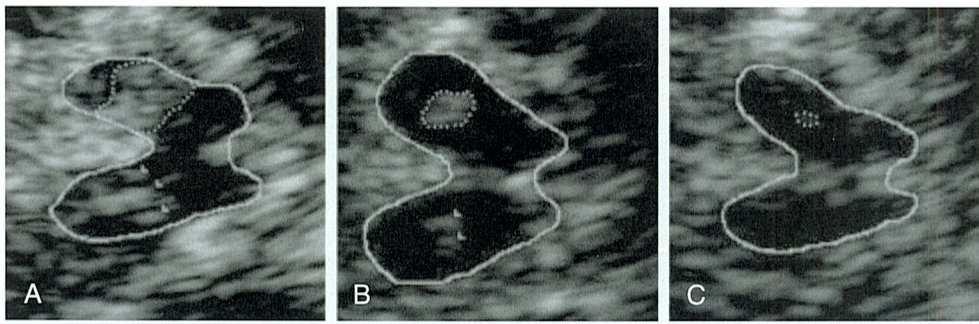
Decreased iron concentration in substantia nigra (SN) of restless legs syndrome (RLS) patients (transcranial sonography). Representative ultrasound images of the human mesencephalic brainstem. SN (encircled with *dotted line* on the side of insonation and marked contralaterally with *arrowheads*) appears hyperechogenic in the hypoechogenic brainstem area (*solid line*). A, Patient with Parkinson's disease (PD), showing SN hyperechogenicity (SN area $\geq .19$ cm² on one or both sides), which is typical for idiopathic PD. B, Healthy control, showing a regularly sized SN area of echogenicity. C, RLS patient, showing hypoechogenic SN (SN sum area of both sides ≤ 0.2 cm²); SN is often not delineable contralaterally. (From Godau J, Schweitzer KJ, Liepelt I, Gerloff C, Berg D. *Substantia nigra hypoechogenicity: definition and findings in restless legs syndrome*. *Mov Disord*. 2007;22:187-192. Copyright 2007, with permission from John Wiley and Sons.)
